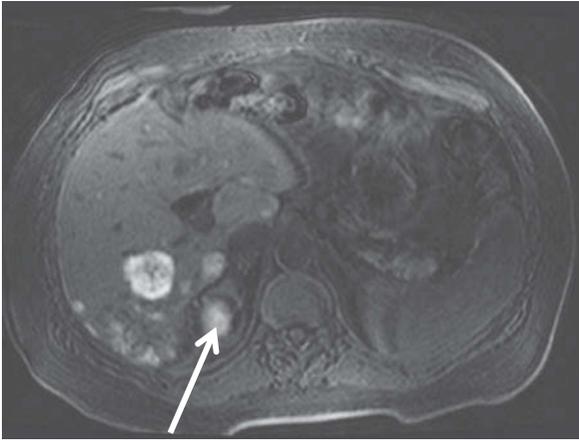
Melanoma metastases. Axial T1-weighted fat-saturated image obtained before administration of contrast demonstrate multiple T1-bright liver lesions compatible with metastatic melanoma. Arrow denotes additional metastatic lesion in right adrenal gland.
